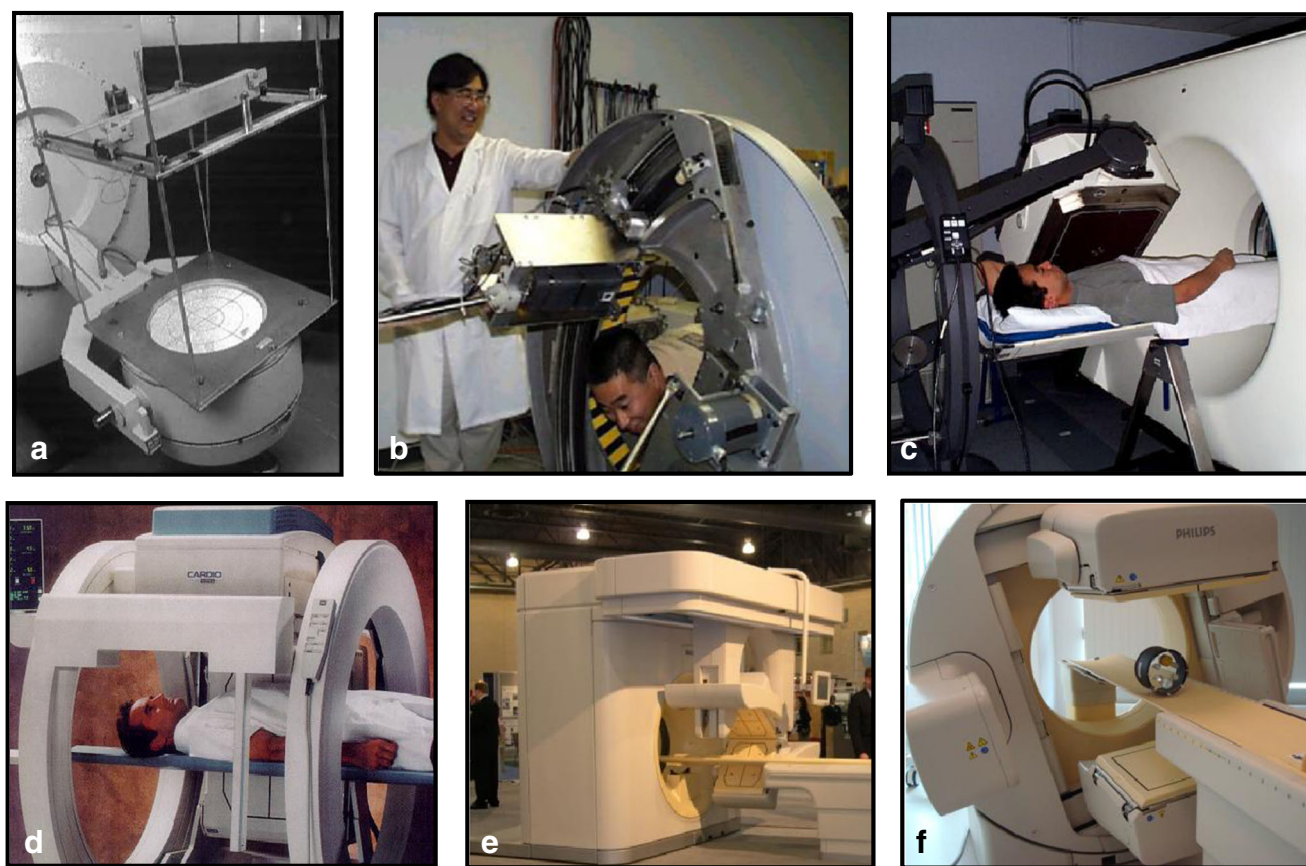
Development of transmission scanning and SPECT/CT. a The original scanning line source in Sydney (1992) [104], b the late Bruce Hasegawa (UCSF) with the first prototype SPECT/CT (1992) [108, 109]; c the UCSF combined use of SPECT and CT (1996) [110]. d ADAC's
